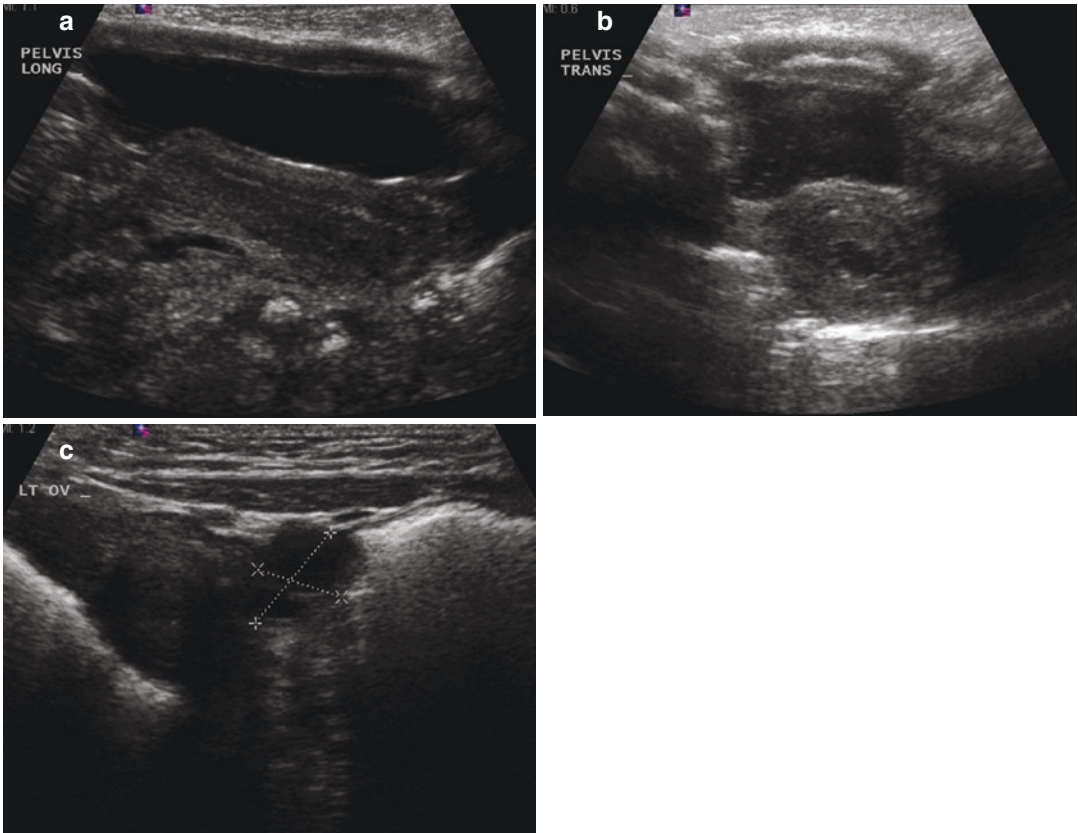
Female Pelvic Ultrasound: (a) Sagittal view demonstrates the uterus. Note echogenic endometrial stripe and rectum posteriorly. (b) Transverse image through bladder and uterus. (c) Ovary with follicles identified
